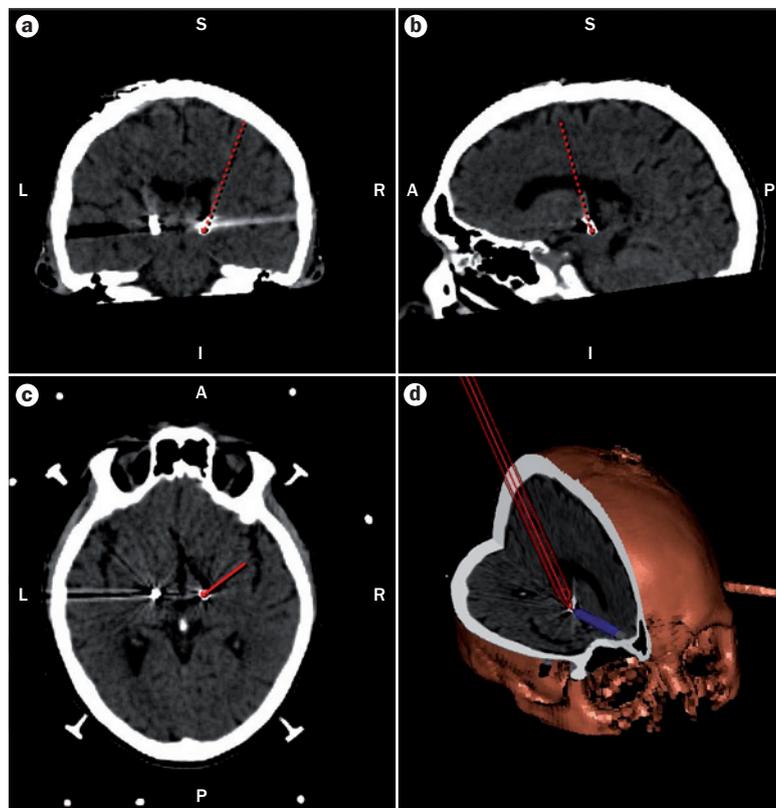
Stereotactic mapping of the brain of a patient undergoing deep brain stimulation. The images show the positioning of macroelectrodes implanted bilaterally in the subthalamic nucleus. a | Coronal CT view. b | Sagittal CT view. c | Axial CT view. d | Reconstructed 3D image, confirming location of the electrodes in the subthalamic nucleus. Red lines in all panels depict trajectory of electrode. Blue line points to tip of right electrode within subthalamic nucleus. Panels a–c were constructed by fusion of preoperative MRI and postoperative CT images, and panel d is a reconstructed 3D image. All images are from the same patient. Abbreviations: A, anterior; I, inferior; L, left; P, posterior; R, right; S, superior.
